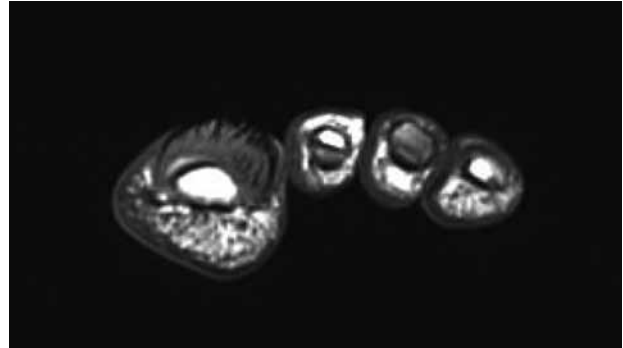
MRI of the nail unit. T1 with gadolinium. Frontal view: Finger-like projections. © Dr E. Terqueux, Montpellier, France
